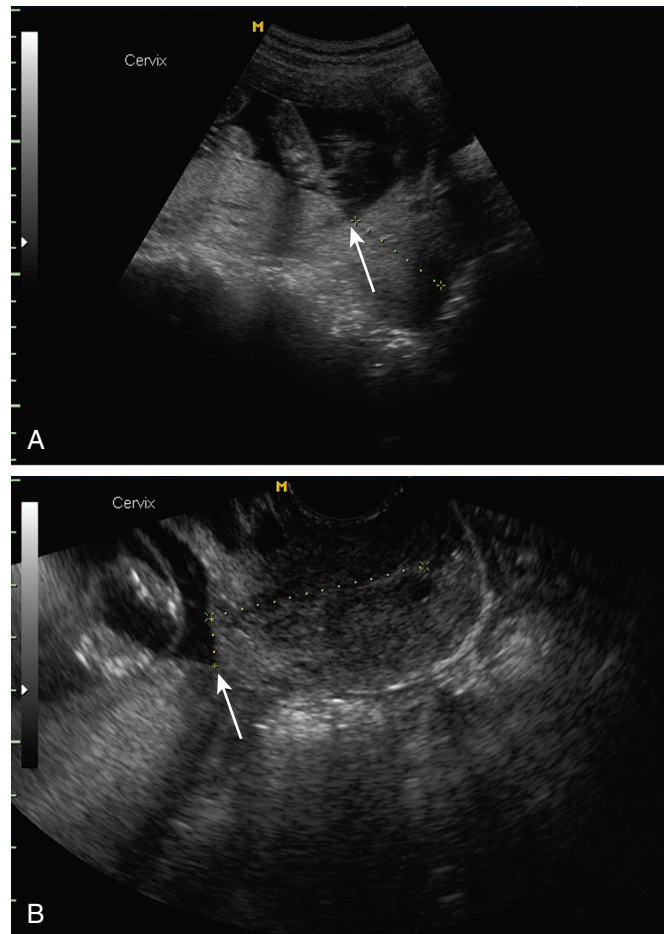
Transabdominal and transvaginal ultrasounds of low-lying placenta. Arrows identify the placental edge. (Courtesy K. Francois.)
